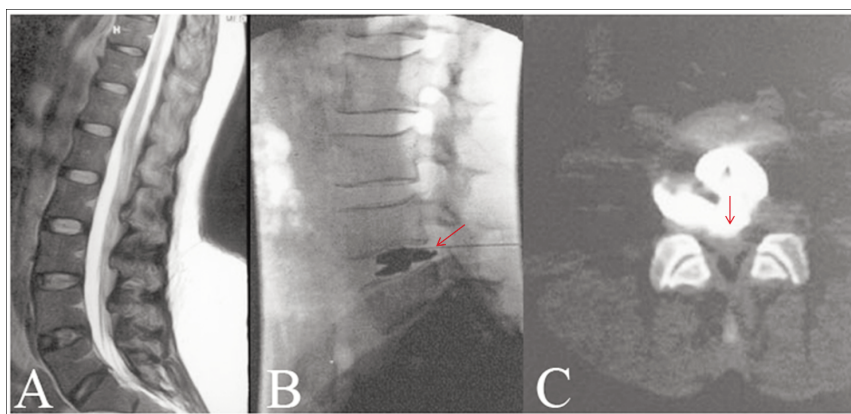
A) Sagittal T2-weighted magnetic resonance imaging showing nothing abnormal; B) discography showing contrast medium in spinal canal; C) computed tomography discography demonstrating a wide-based annulus fibrosus tear.
